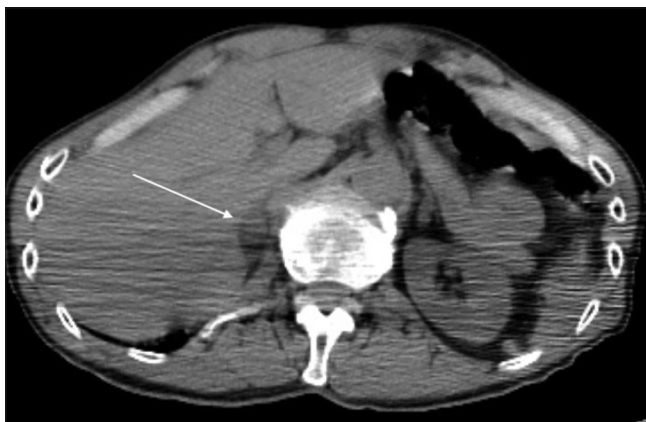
A 65-year-old male with metastatic squamous cell carcinoma. Axial non-contrast-enhanced computed tomography demonstrates a soft tissue lesion in the right adrenal gland (white arrow)
